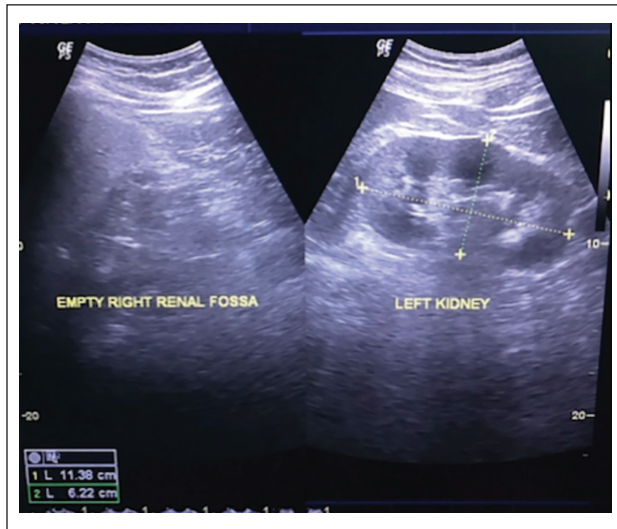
Kidney ultrasound showing an empty right renal fossa with compensatory hypertrophy of the left kidney. No ectopic kidney was found.
